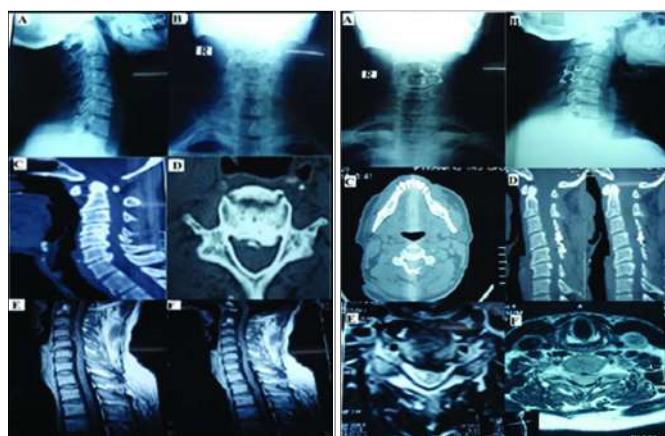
Preoperative images: (A) X-ray cervical spine lateral view; normal lordotic curvature. (B) X-ray AP view showing degenerative changes with osteophytes and facet joint arthrosis. (C) CT scan sagittal view showing osteophytes & reduced disc height. (D) CT axial view showing degenerative changes along with canal diameter compromise. (E & F) MRI Sagittal view showing growth of osteophytes and herniated disc.
